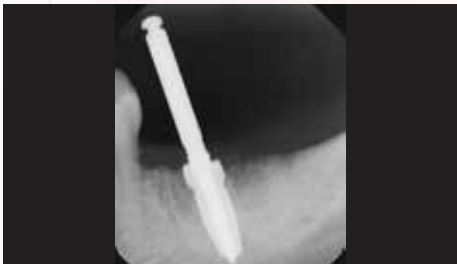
A periapical radiograph of the 4.3-mm-diameter osteotomy bur in place indicates nice position at the crest of the edentulous ridge.
